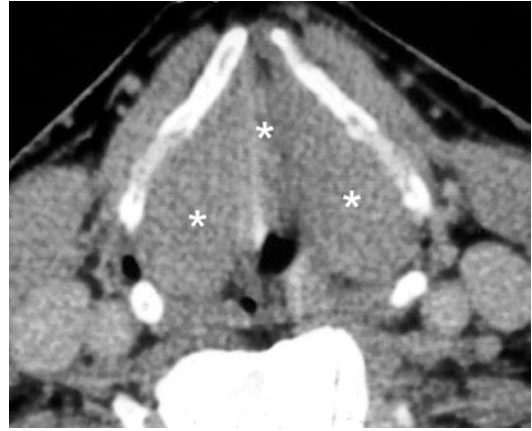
Axial contrast-enhanced CT image shows diffuse soft tissue infiltration of the deep fatty laryngeal spaces (paraglottic and preepiglottic space), corresponding to non-Hodgkin lymphoma
